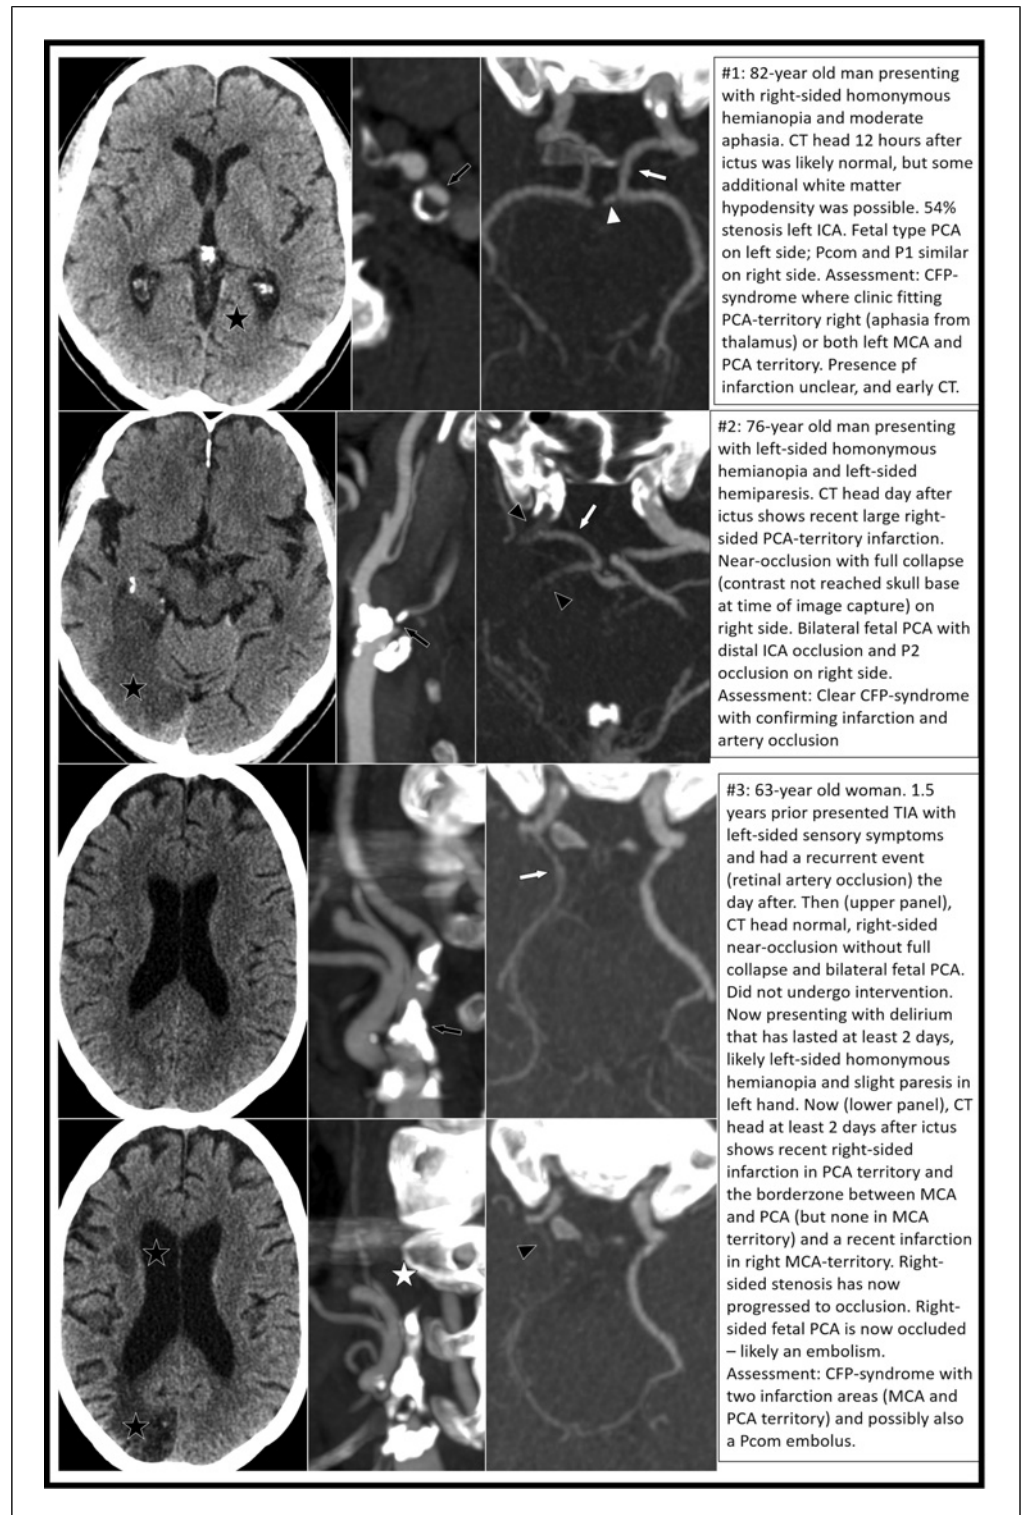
Three cases of CFP syndrome (first two has a single panel/row, the third has two panels/rows). All: plain CT head, CTA of the stenosis, and of the P1-P2-Pcom part of the Circle of Willis. Black arrow: stenosis. Black arrowhead: embolic occlusion. White arrow: ipsilateral Pcom. White arrowhead: P1. Black star: recent infarction (around or adjacent to the star). White star: occluded ICA.
